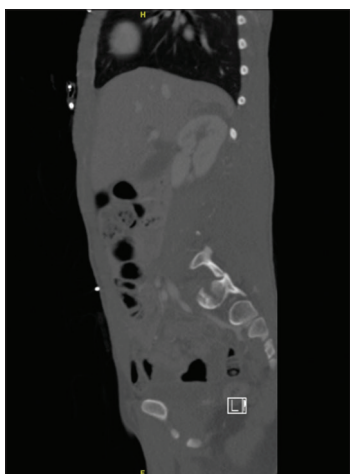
CT abdomen and pelvis with contrast demonstrating left L5–S1 locked facet.
